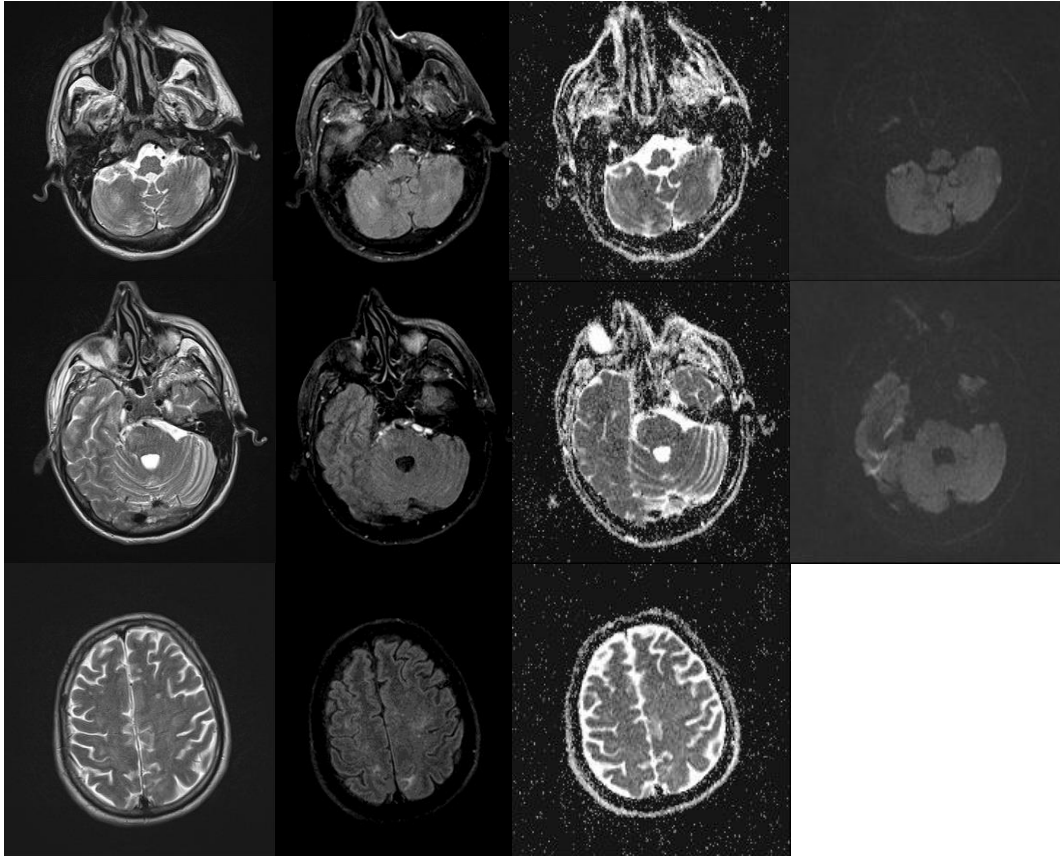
Brain MRI-hypersignal lesions on T2 and FLAIR without diffusion restriction, hyperintensity on ADC map dominantly in posterior circulation, cerebellum, pons and parietooccipital regions billateral subcortical with vasogenic edema in few of them. PRES in subacute phase.
